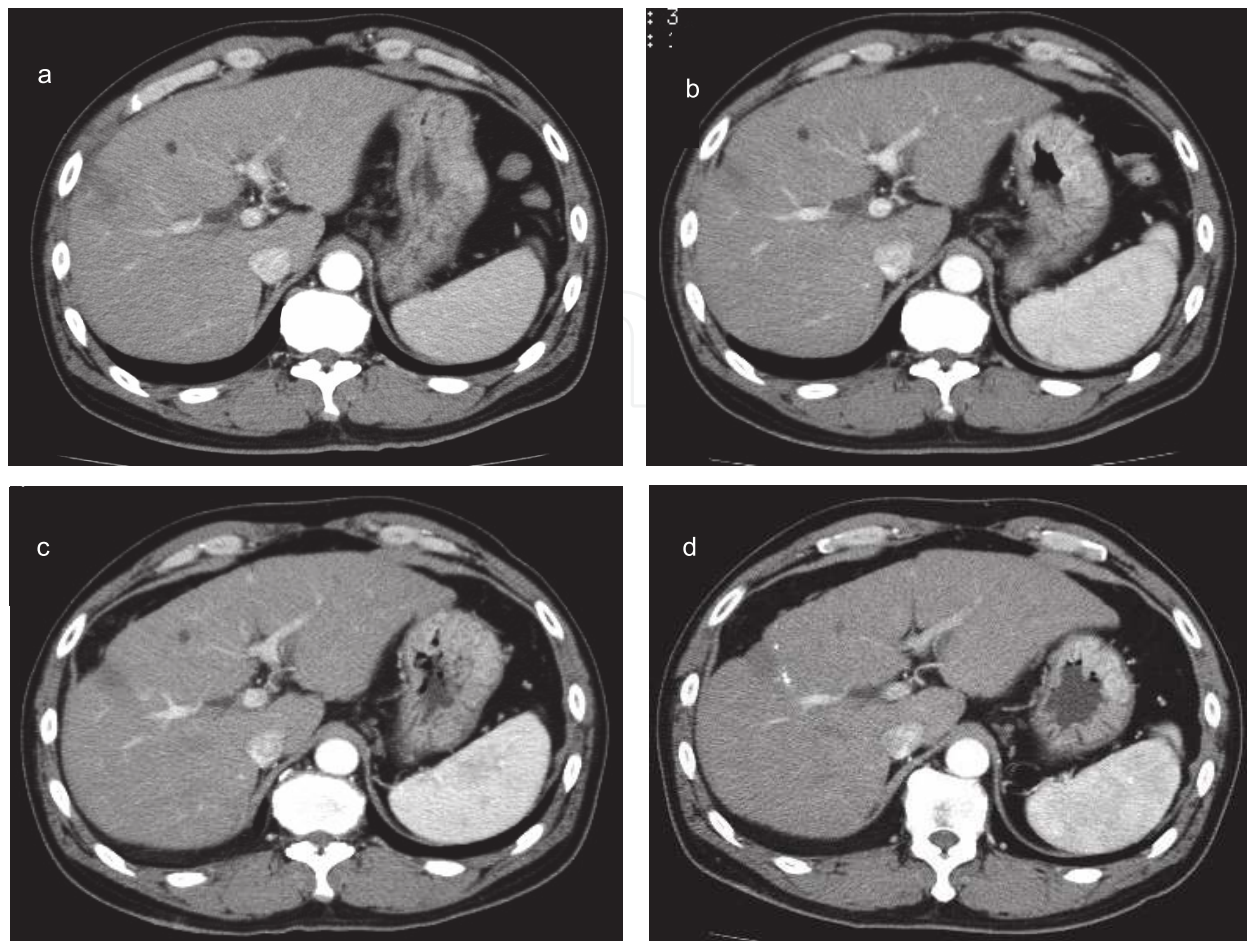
Computed tomography scan obtained after the radiofrequency ablation therapy. (adapted from Nawa T et al).
